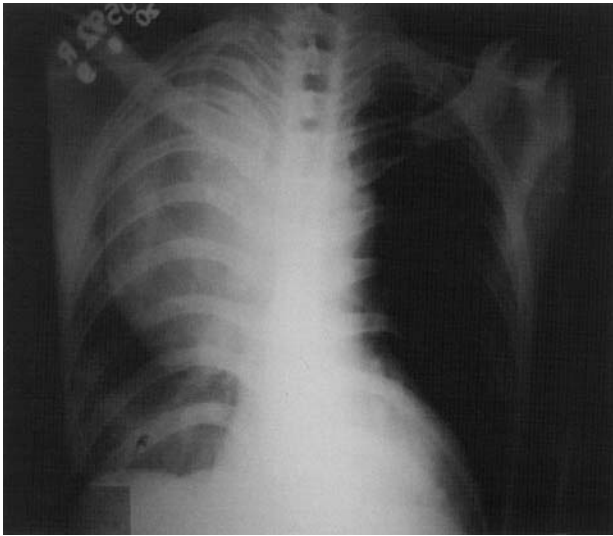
Chest radiograph (postero-anterior view) showing large radio-opaque shadow in the right hemithorax displacing right lung laterally.
